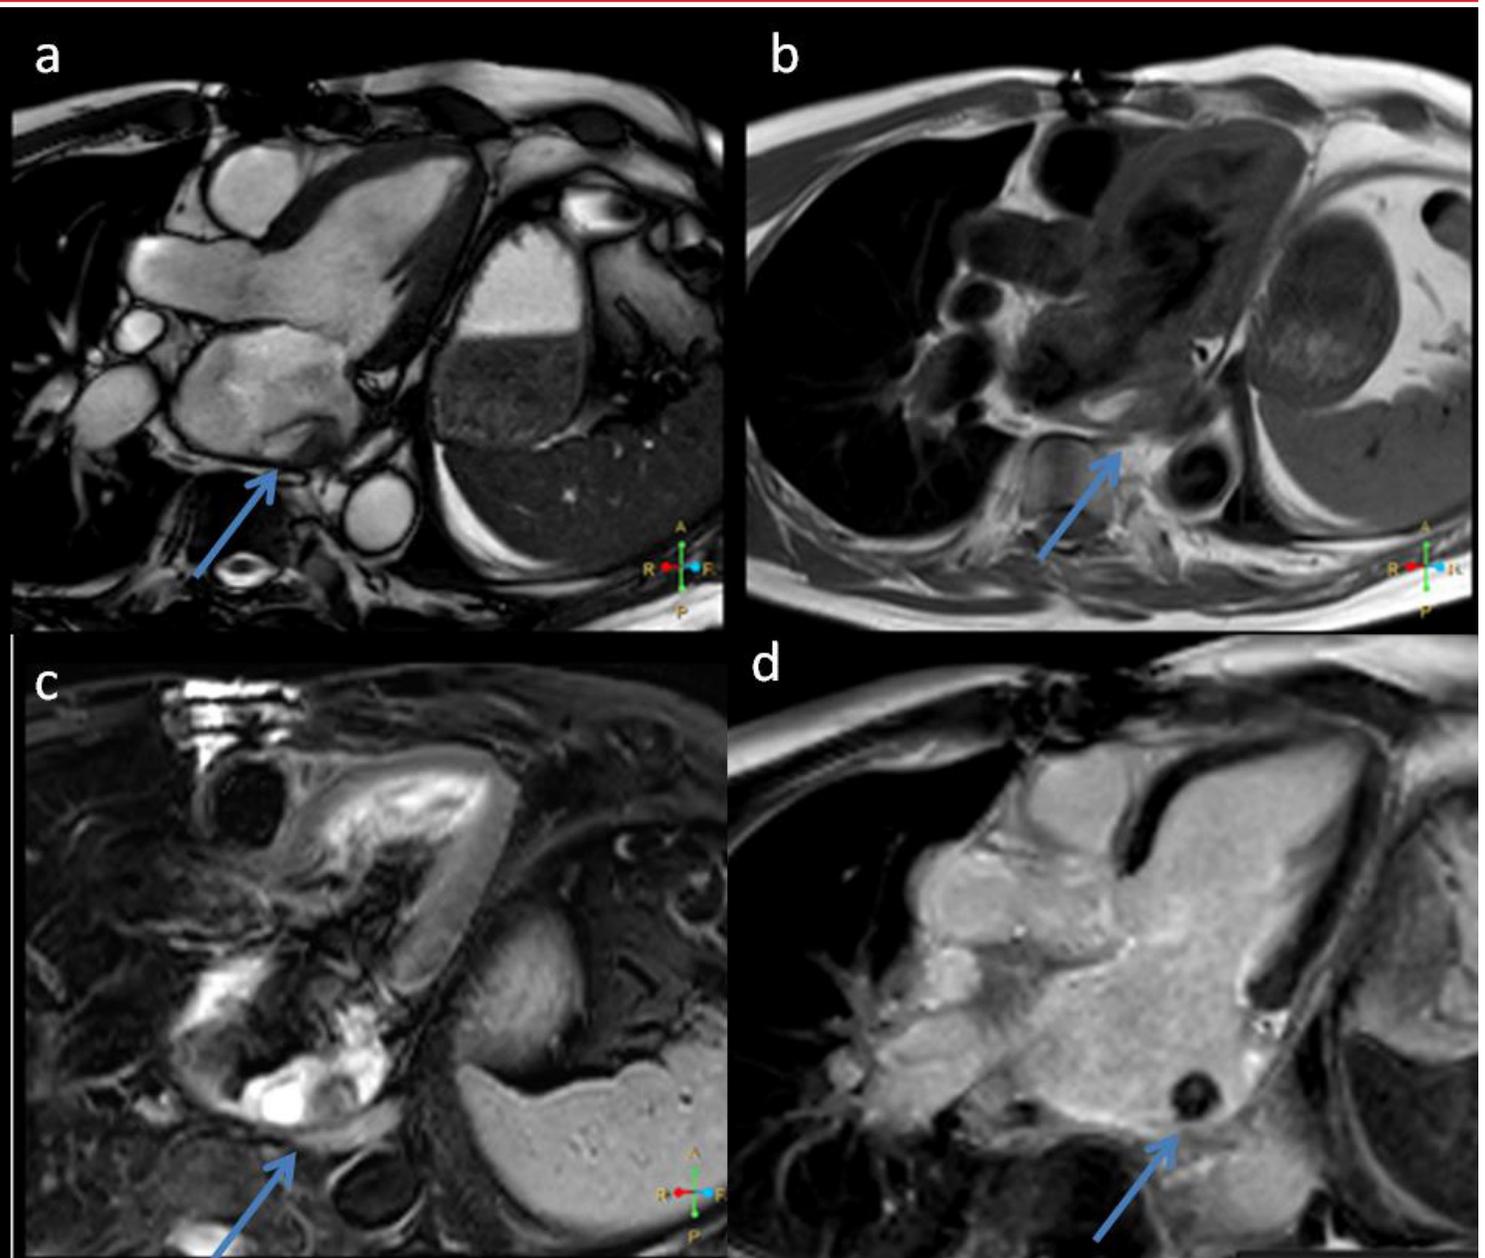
Left atrial mass at the time of initial diagnosis (a-d). a, cine still frame; b T1-weighted turbo-spin echo; c, blackblood T2-weighted turbo-spin echo; d, late-gadolinium enhancement imaging.
